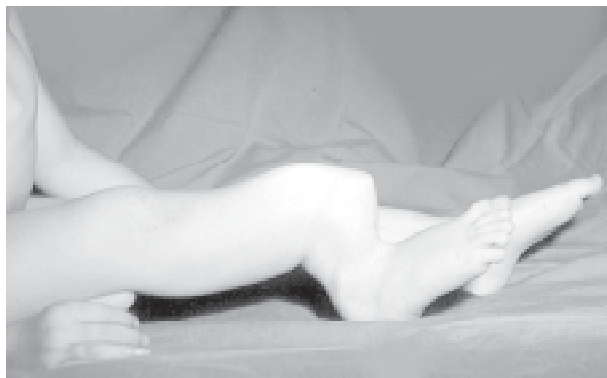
(a,b) Clinical (a) and X-ray lateral (b) view to show present condition after progressive bowing of lower leg due to poorly managed tibial avulsion fracture.
